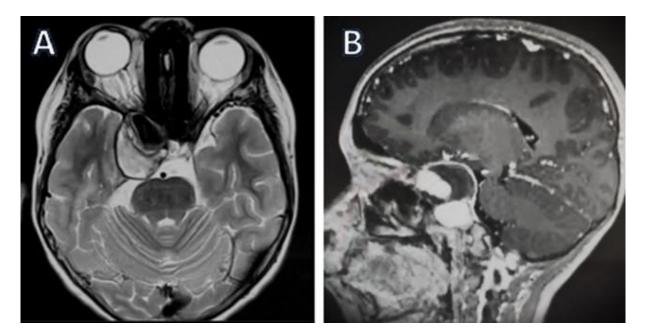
MRI, axial (T2), and sagittal (T1) views show an aneurysm of 54mm in diameter partially thrombosed in the cavernous segment of the right ICA.
